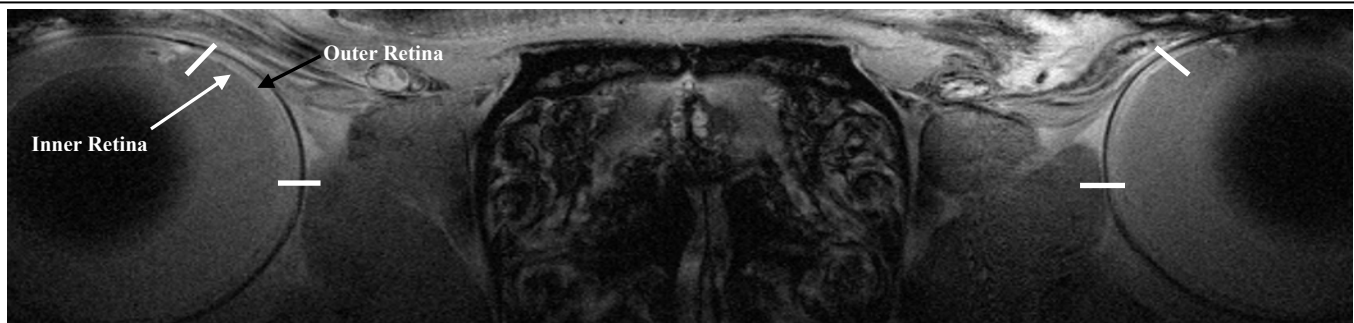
MRI at $39 \times 39 \mu\text{m}$ image taken after 135 min time point. The outer retina is indicated by black arrow, the inner retina is indicated by white arrow. Region used for intensity profile analysis is located between white bars. Signal intensity profiles were taken in the direction from sclera to the vitreous.
